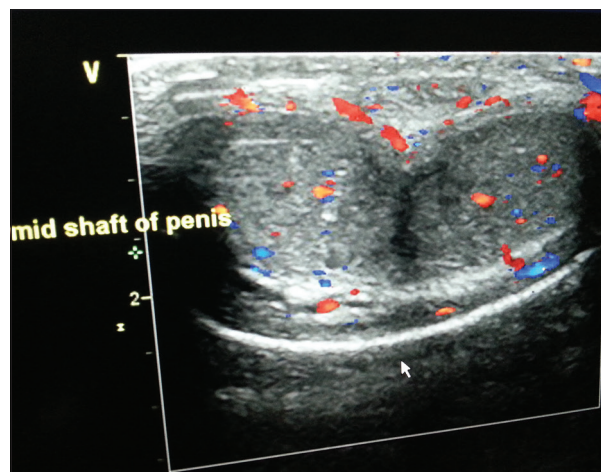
Penile Doppler showed no flow into the corpora cavernosa
